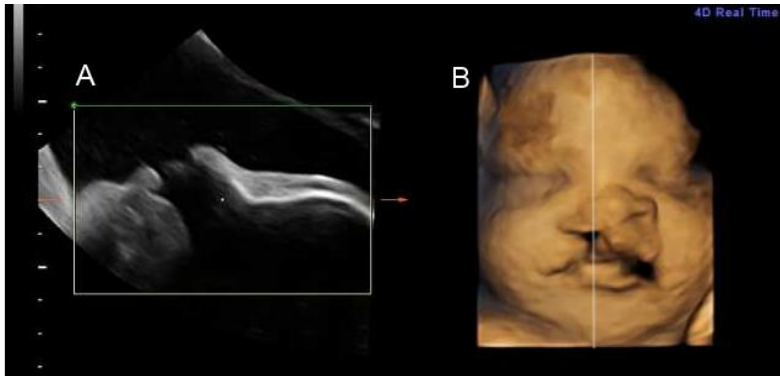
Prenatal ultrasound at 37th week of pregnancy. Sagittal section (A) and three-dimensional surface image of the face showing a right sided complete cleft lip and palate (B).
